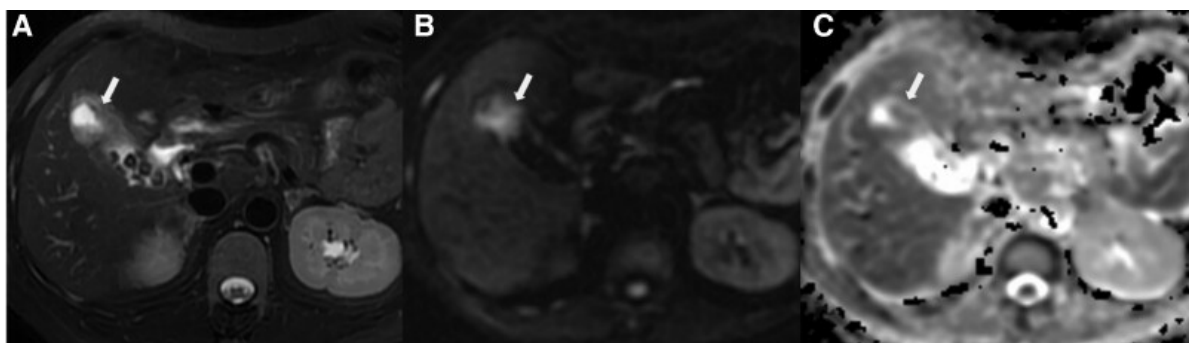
(a-c): Moderately to poorly differentiated gallbladder adenocarcinoma in a 59-year-old female, (a) T2WI fat-sat shows focal fundal wall thickening without layered appearance and papillary growth, (b) DWI demonstrates localized hyperintensity, (c) ADC map shows corresponding hypointensity, confirming non-layered thickening
